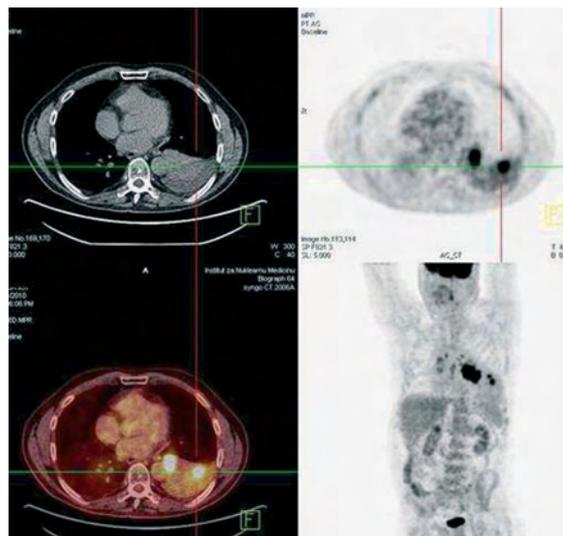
Increased focal uptakes of F-18-FDG in the left lung indicate NSCLC viable tumor tissue. FDG-PET/CT helps in directing the radiation towards the metabolic active tumor and in sparing the non-tumor collapsed lung tissue
